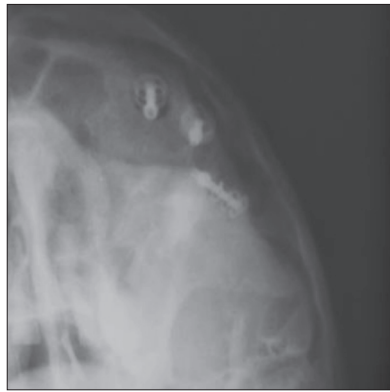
Waters projection radiography showing osteoradionecrosis bone damage around implant
